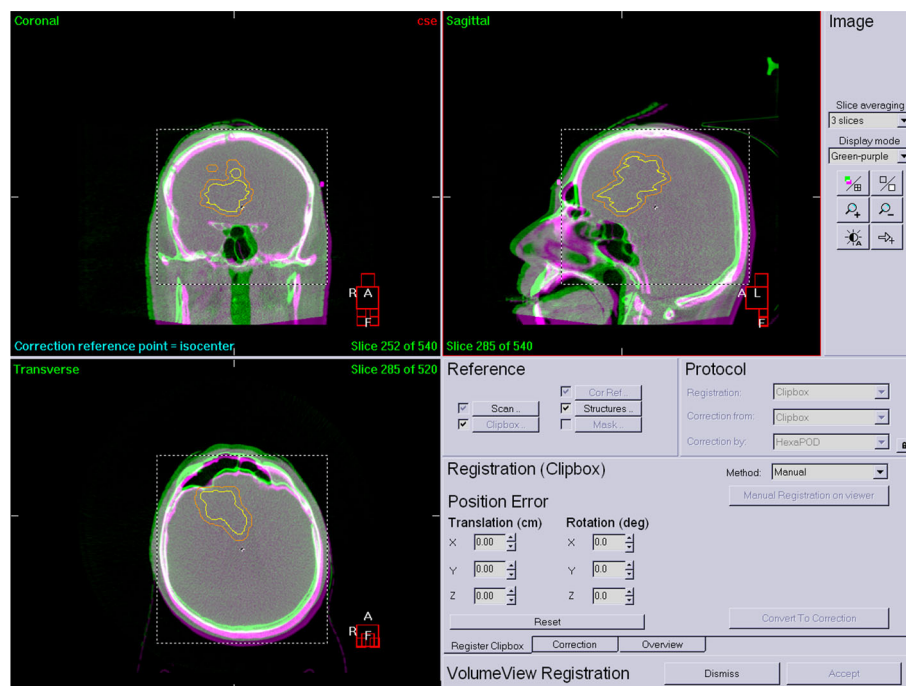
shows the results of a post-treatment HR CBCT, where intrafractional motion would appear (Figure 5).
